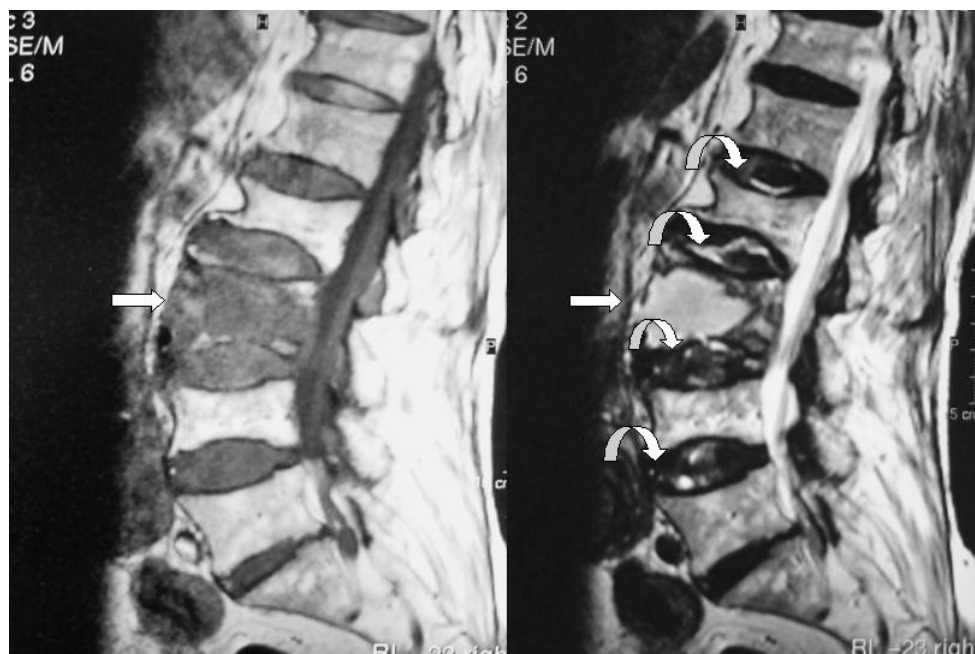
In contrast to the initial MRI, repeated MRI on the tenth day of admission revealed a heterogeneous decreased signal lesion in the vertebrae of L-3 on T1-weighted image (arrow, left panel). On T2-weighted image (right panel), an irregular hyperintensity lesion in L-3 (arrow), and linear dot-like hyperintensities (curved arrows) are noted within L1/2~L4/5 intervertebral discs. Osteomyelitis of L-3 and discitis in L1/2~L4/5 intervertebral discs are highly suspected.
